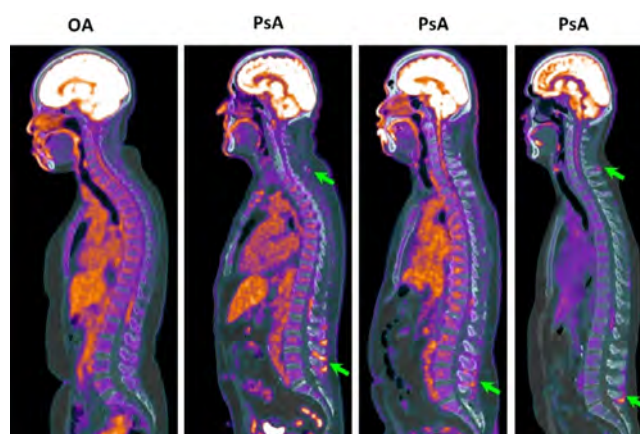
PET-CT in Diagnosis of Psoriatic Arthritis Axial Disease. Enthesitis at multiple levels in the spine (green arrows) with or without sacroiliitis is an interesting finding in the psoriatic arthritis (PsA) patients by total body the PET-CT imaging. Whereas in osteoarthritis (OA) spinal inflammation could not be detected. Involvement of the inter-/supra-spinous ligament are marked by the green arrows.
